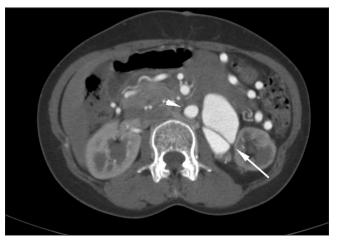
Computed tomography angiogram showing abdominal aorta (arrowhead) and aneurysmal Dacron graft with flap (arrow)
